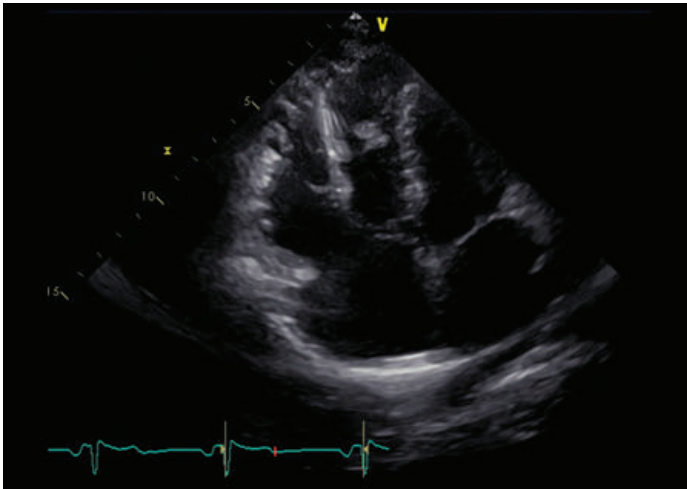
2 Echocardiographic image (modified apical 4-chamber view) of the right ventricle in a patient with ARVC/D diagnosed according to the revised Task Force Criteria.⁴ The right ventricle is dilated, and several aneurysms are detectable in the midventricular and apical lateral wall. The reverberating structure in the center of the right ventricle is an ICD electrode.
